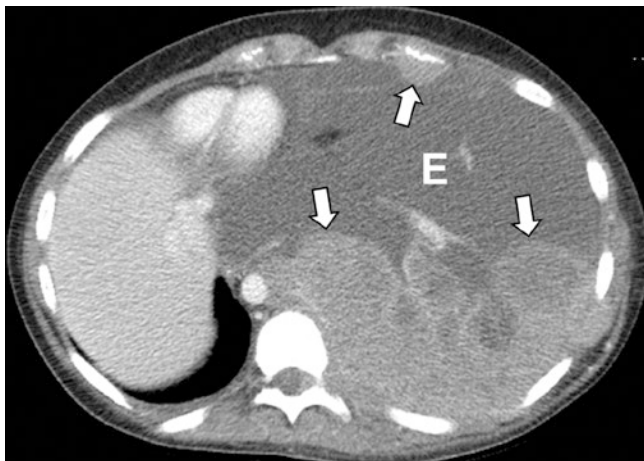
A 16-year-old girl with malignant pleural effusion due to metastatic rhabdomyosarcoma. Enhanced axial CT image shows multiple pleural-based enhancing metastases (arrows) and large left effusion (E)
